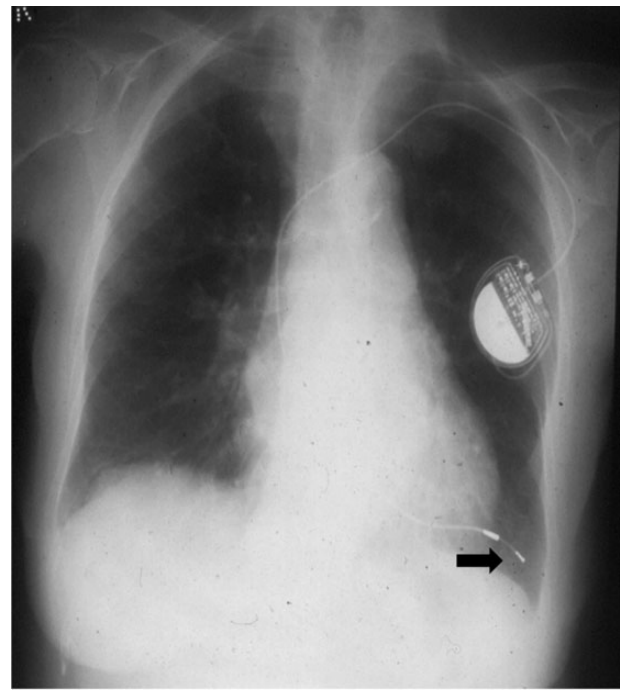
Chest radiograph demonstrating right ventricular lead migration (arrowed) outside of the heart.
